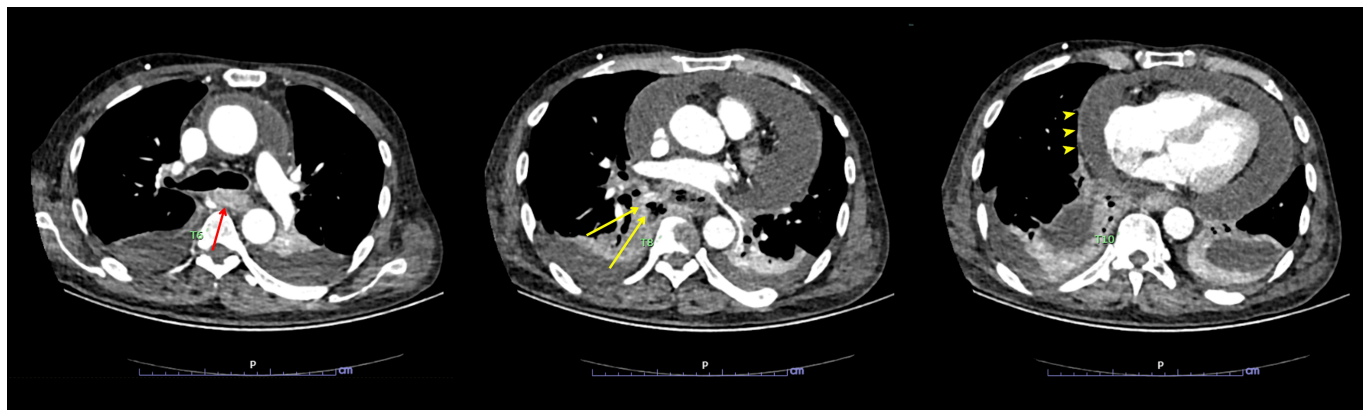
CT of the chest (axial view) showing a circumferential thickening lesion at mid-thoracic esophagus about level of T6 spine (red arrow), measuring $1.9 \times 4.2 \times 3.0$ cm in maximal axial and vertical diameters, with track-like lesion extending from the right side of this lesion containing fluid and multiple air bubbles contiguous from the right side of the esophagus (yellow arrows). Also, a moderate amount of pericardial effusion with thin smooth enhancing wall (arrowheads), measuring 2.7 cm in thickness.
